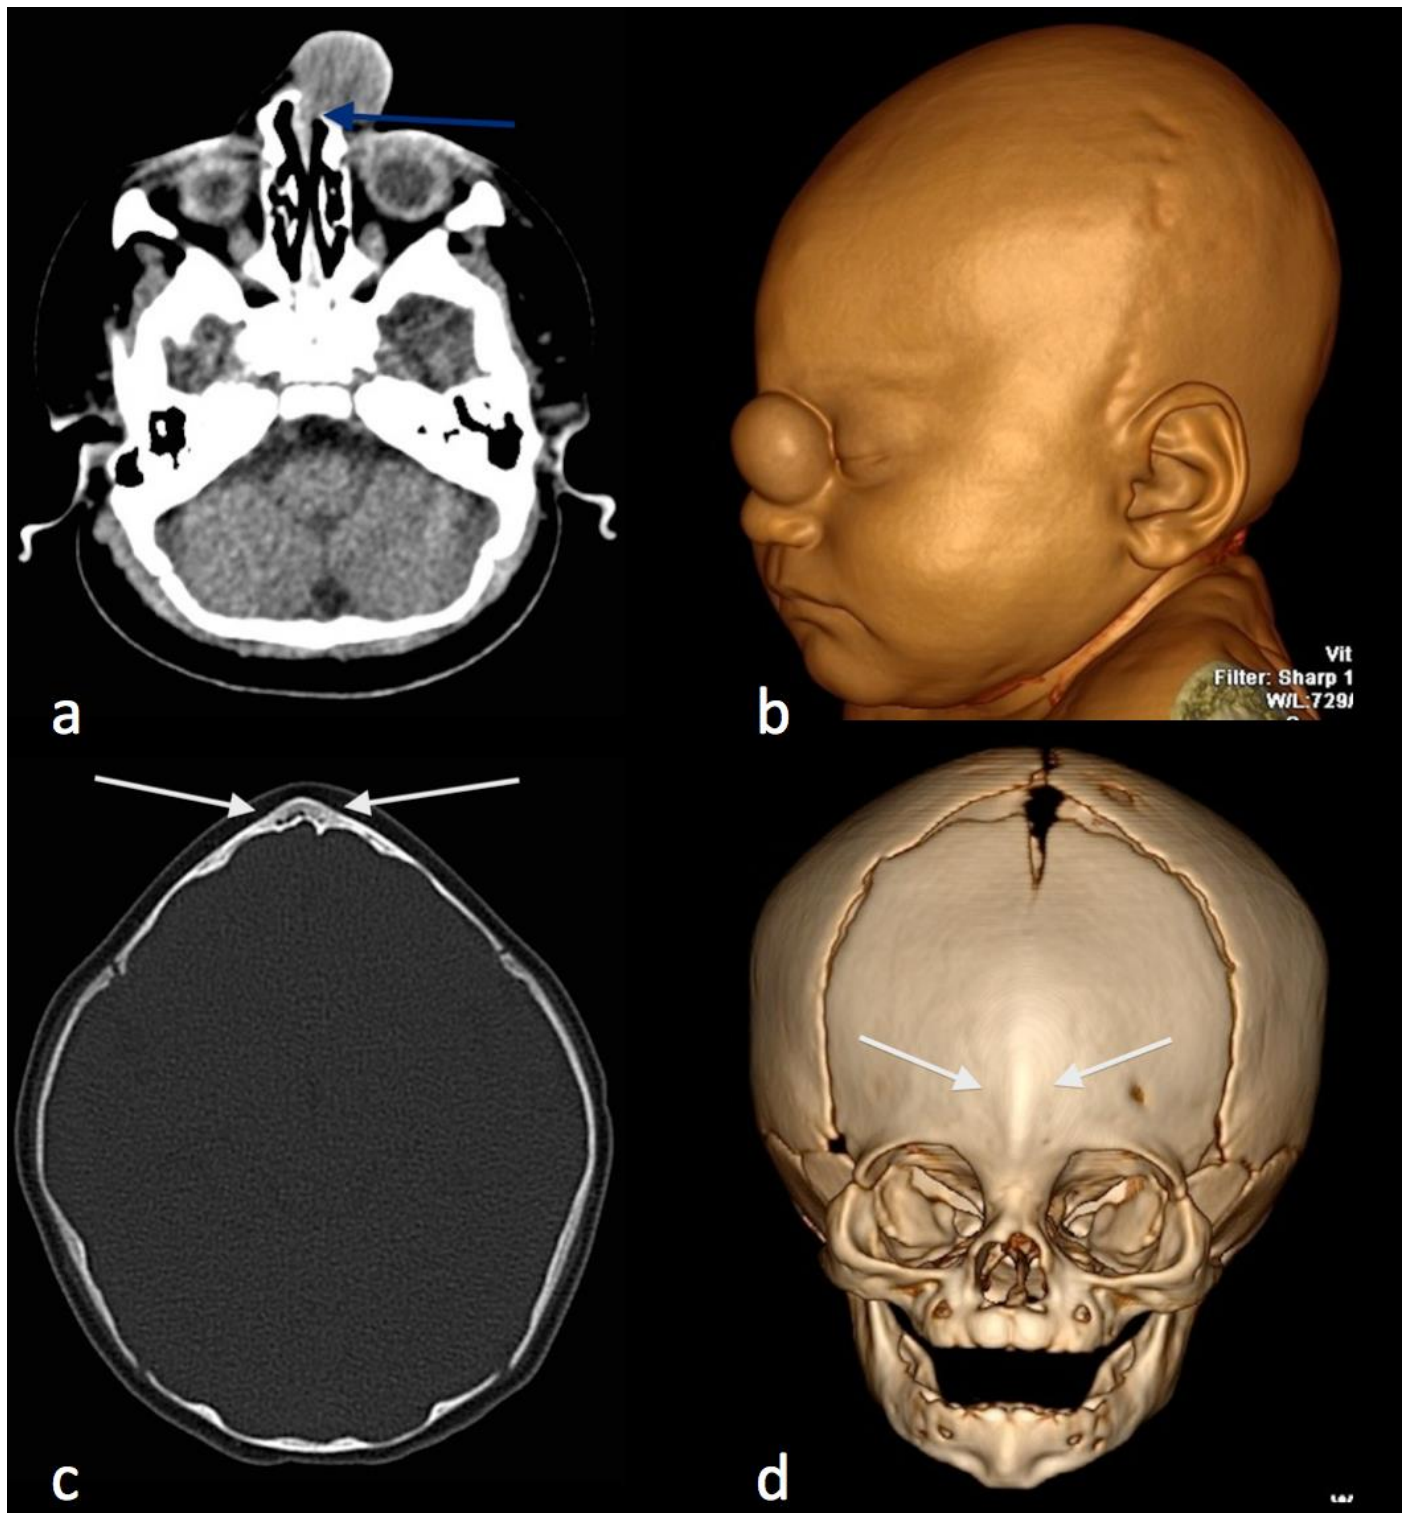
2 month old female with nasal glioma and trigonocephaly. Axial head CT in soft tissue windows (a) demonstrates subtle extension of the nasal glioma into the nasal cavity (blue arrow). 3-dimensional soft tissue (b) demonstrates the paramidline, supra-nasal location of the nasal glioma. Axial CT in bone windows (c) and 3-dimensional frontal image (d) demonstrate premature closure of the metopic suture with trigonocephaly. Technique: 64-row multidetector sensation CT, Siemens, Germany, 240 mas, 100kVP, 1.0 mm reformation. 3D reconstructions using Vitrea, Toshiba Corporation, Japan.
